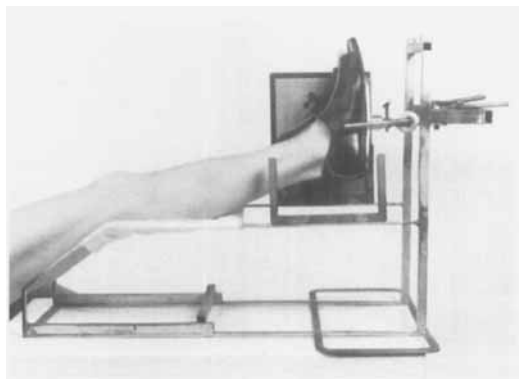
Apparatus used to standardize the radiographic examination.
